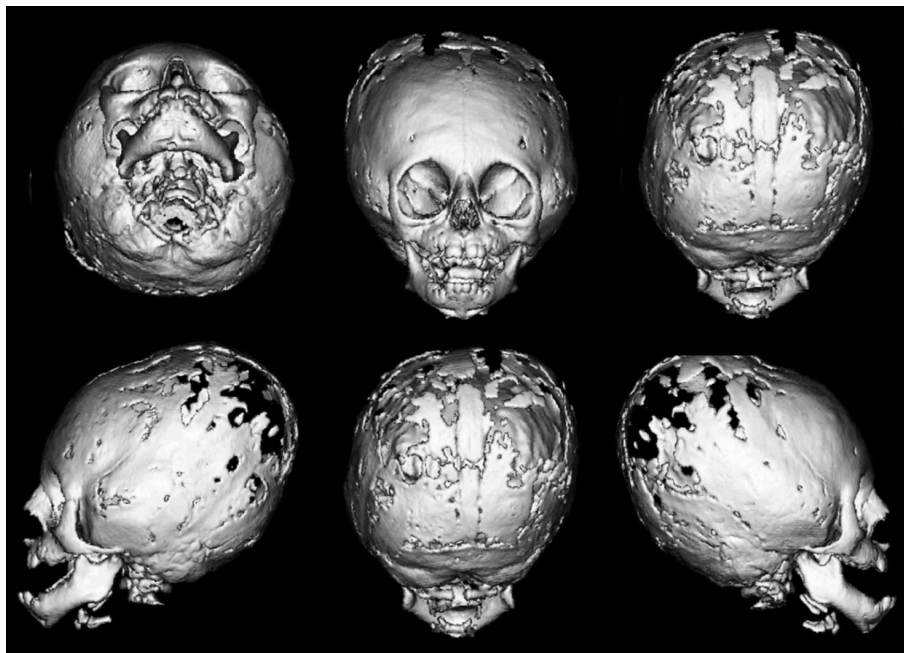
Preoperative 3D CT scan of 11 months old patient with Crouzon syndrome.
